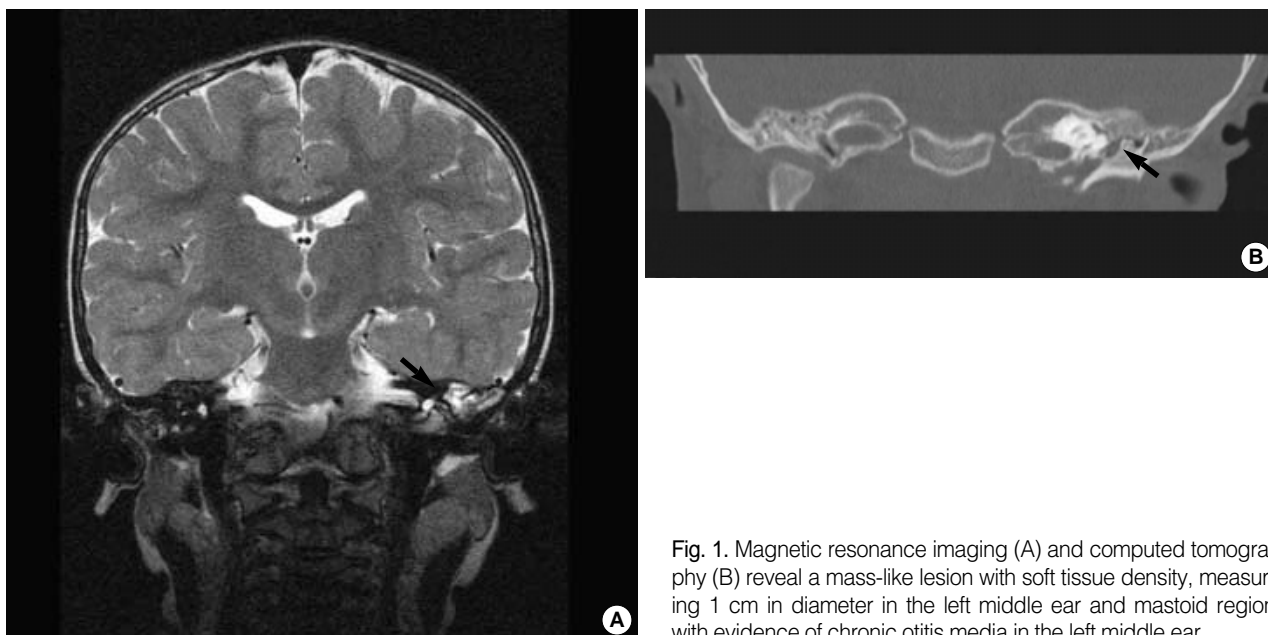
Magnetic resonance imaging (A) and computed tomography (B) reveal a mass-like lesion with soft tissue density, measuring 1 cm in diameter in the left middle ear and mastoid region with evidence of chronic otitis media in the left middle ear.
